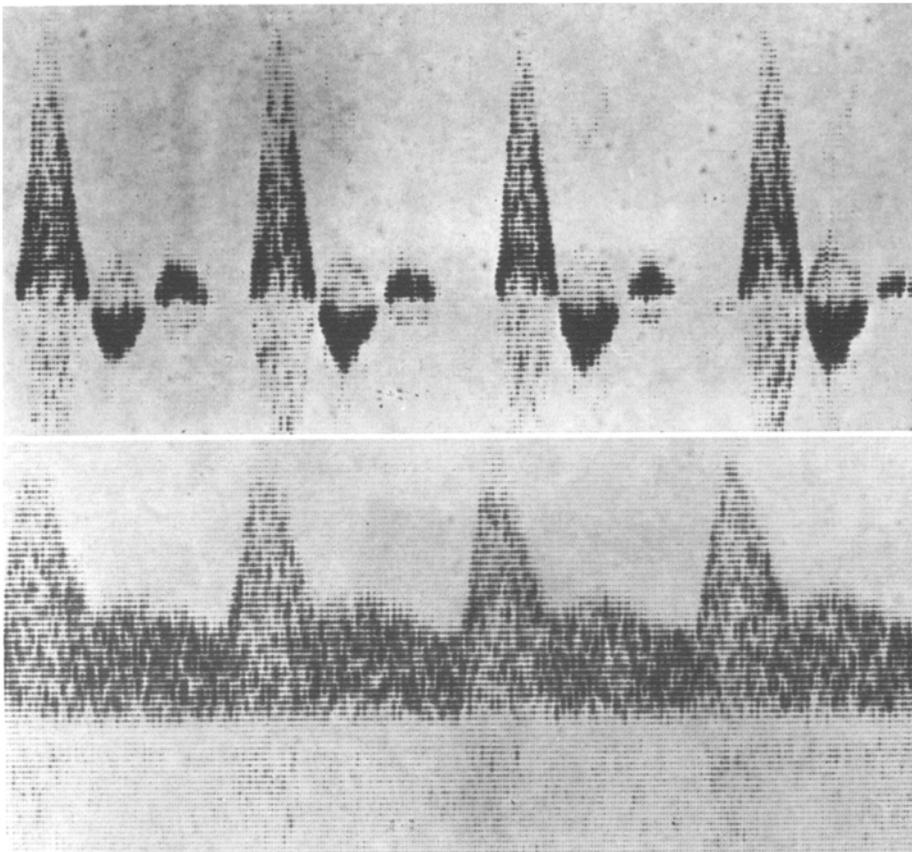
Sonograms from dorsalis pedis artery of a control subject (above) and a neuropathic subject with Charcot joint (below)
